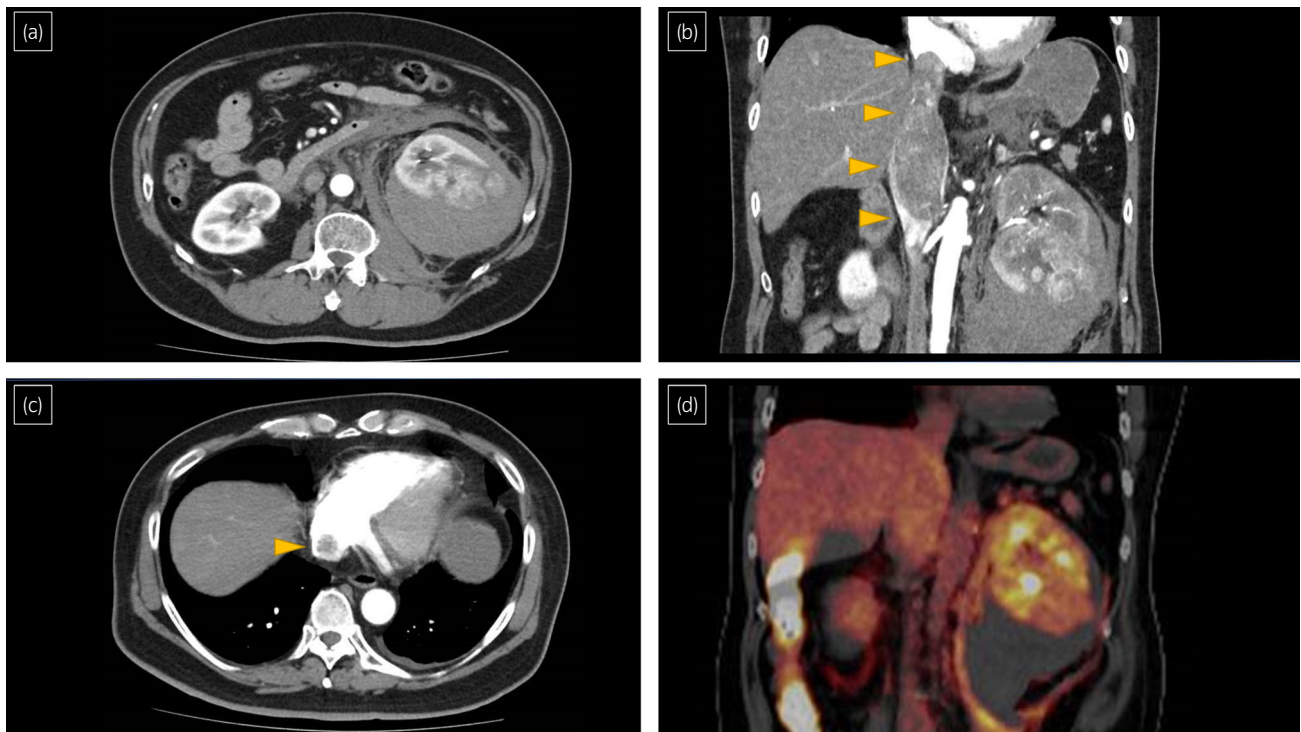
Computed tomography (CT) images of the left renal tumor (a, b) and vena cava thrombus (b, c). Fluorodeoxyglucose-positron emission tomography (FDG-PET) CT imaging showing FDG uptake in the primary tumor and vena cava thrombus (d).
